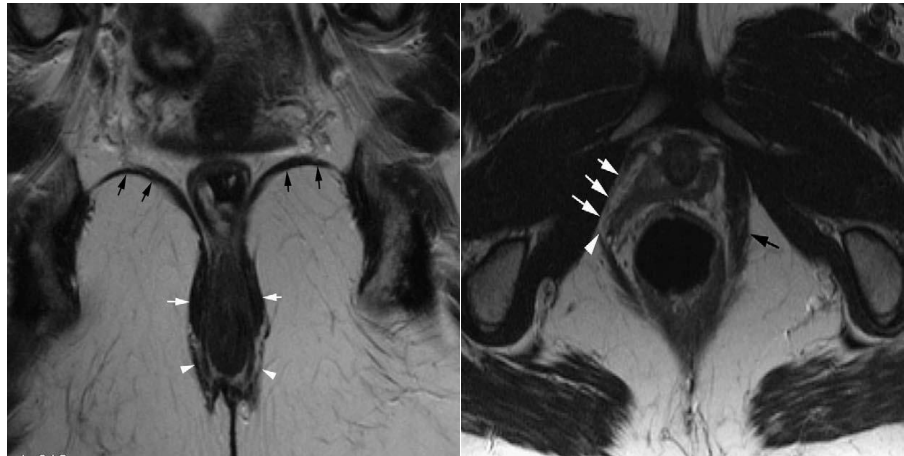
MRI with high resolution coronal T2 weight image in female without defective tissue (left) and MRI with high resolution axial T2 weight image in female patient with recurrent prolapse (right). In the normal female, the ICM (black arrows), PRM (white arrows) and EAS (arrow heads) are anatomically well positioned within the surrounding pelvic fat. In the clinical case the right pubovisceralis muscle has been completely avulsed (arrow head), with no remaining muscle in its usual position (white heads) and the opposite side shows an intact muscle (black arrow) [114].
